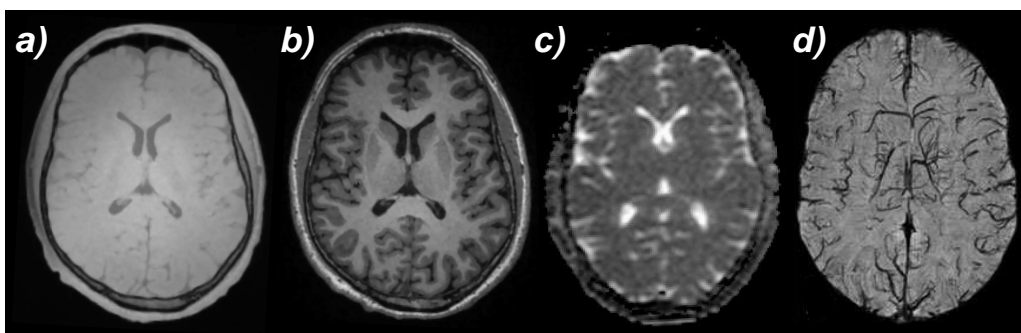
Different MRI contrasts of the transverse brain slice: (a) hydrogen density based contrast, (b) T_1 relaxation based contrast [Güllmar, 2008], (c) particle diffusion based contrast [Hiepe, 2009] and (d) magnetic susceptibility based contrast [Deistung et al., 2008].
